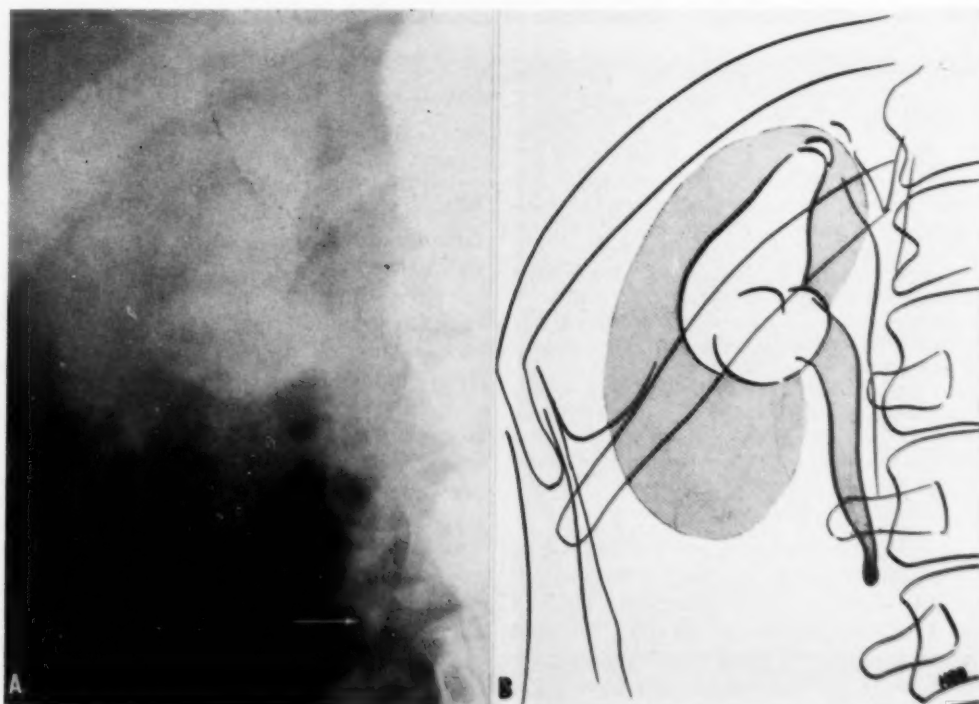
A. Roentgenogram obtained one hour after injection of Cholografin, showing a normal appearing gallbladder and calcification thought to be in the common duct.
